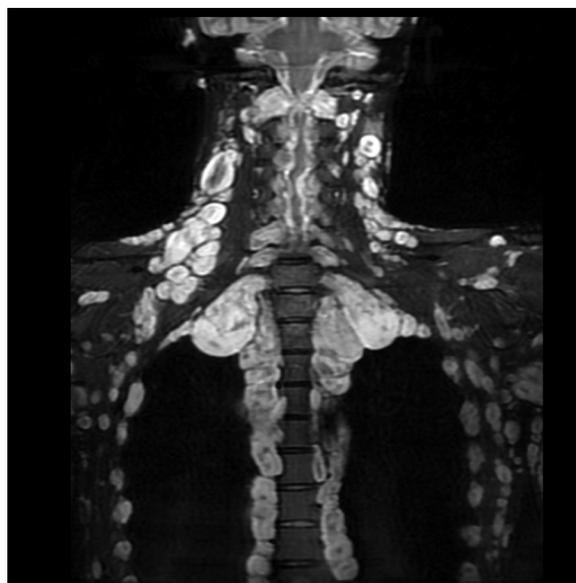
Coronal STIR MRI of the neck 42 months later showed more pronounced side-to-side cord compression by progressive enlargement of the intradural components of the segmental tumours.
